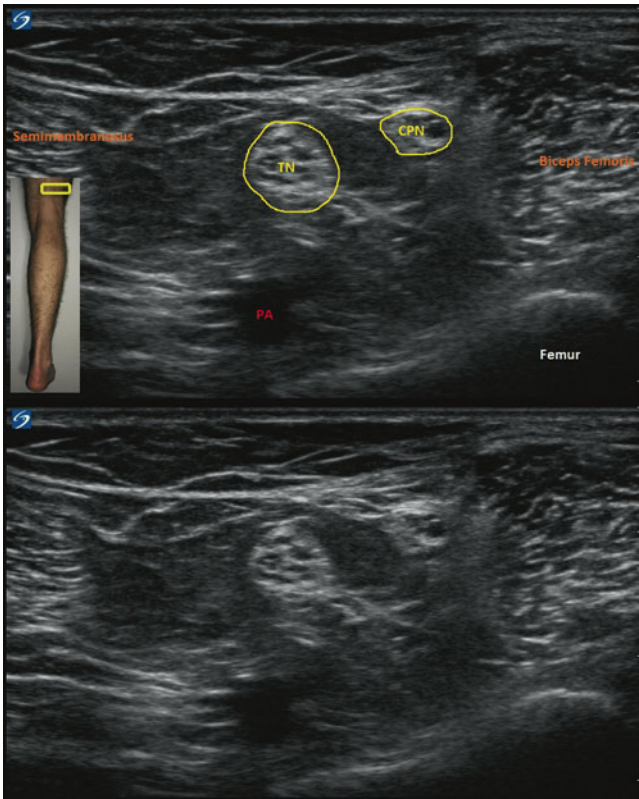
Ultrasound identification of the sciatic nerve splitting into the common peroneal nerve and the tibial nerve. *PA* popliteal artery, *TN* tibial nerve, *CPN* common peroneal nerve (Image courtesy of Agnes Stogicza, MD)
